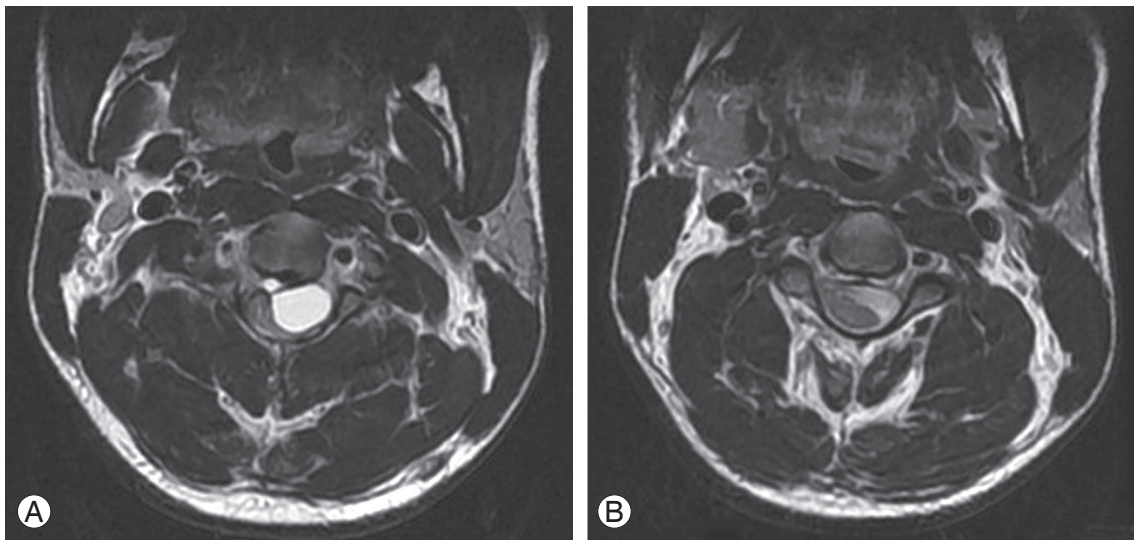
Magnetic resonance imaging of the cervical spine axial T2 weighted images showing a large cystic lesion pushing the cord to the right. (A) T2 weighted and (B) fluid-attenuated inversion Recovery sequence images.
